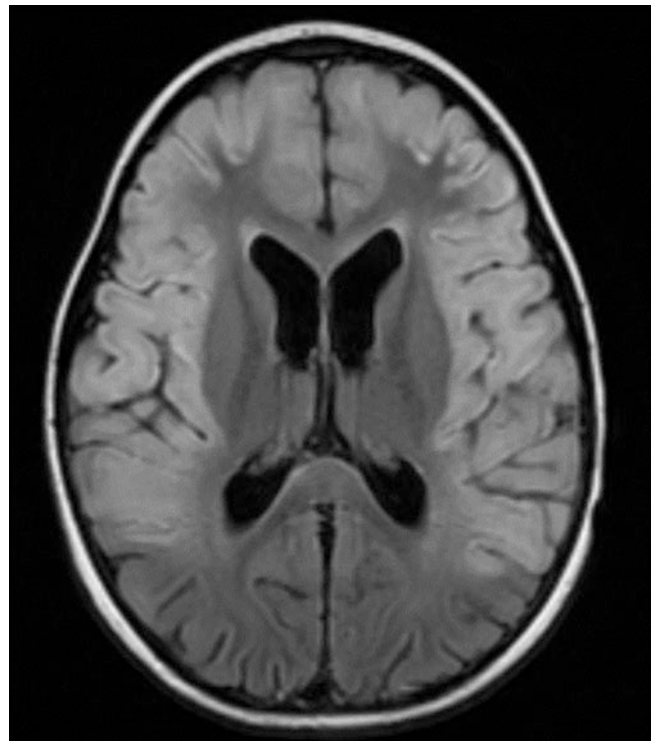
Brain MRI and MRS 5 days after initial presentation, showing diffuse cortical signal changes, edema, and a lactate peak
